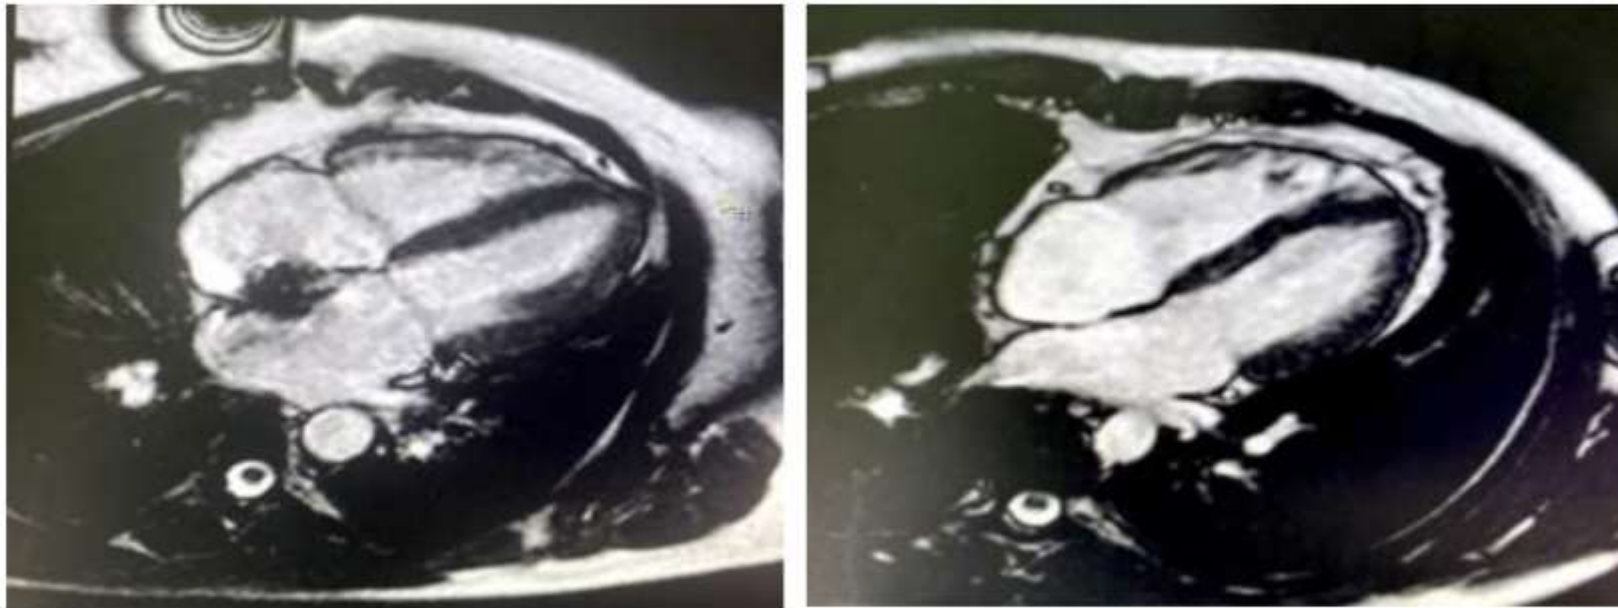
Cine SSFP 4 chamber MRI view in A ) transcatheter closed case by ASD B) surgically closed ASD with complete revolution of both atria and RV .
